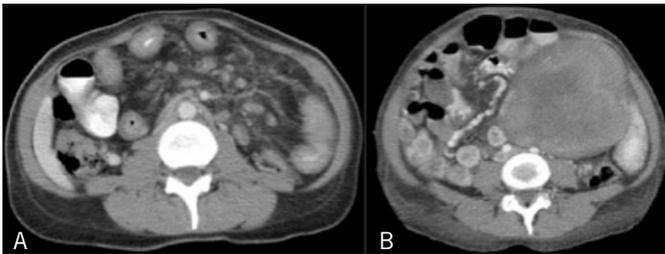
Abdominal CT showing (A) extensive segmental small bowel wall thickening suggestive of Crohn's disease and centrally mesenteric adenopathy, but no distinct mass, and (B) a 12.1 x 10.8 cm enlarging homogeneous, solid mass left of the midline.
